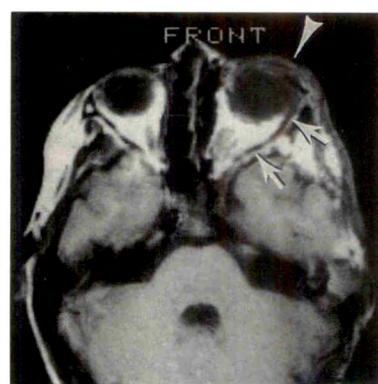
MR imaging findings in 47-year-old man with orbital neurofibroma. Axial T2-weighted (2800/90) image shows multilobular soft-tissue mass involving right optic nerve with markedly increased signal intensity and associated proptosis (arrowheads).
